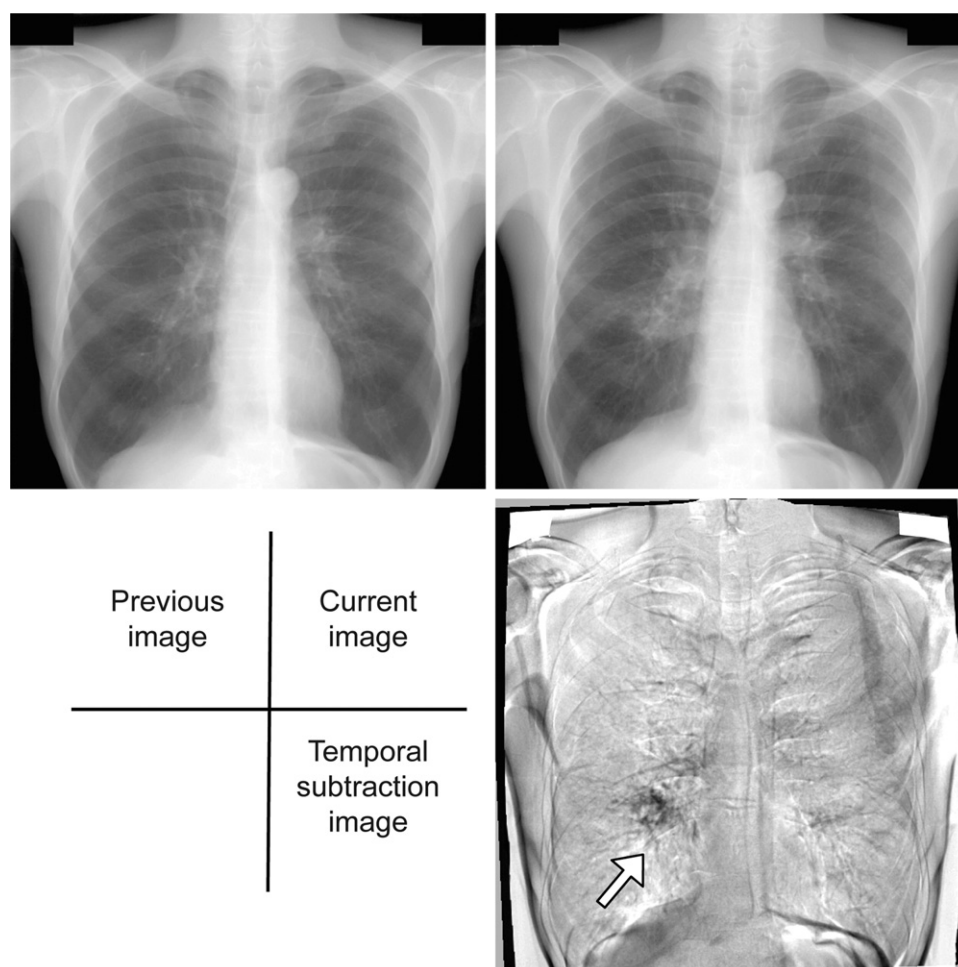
Example of temporal subtraction image in 2 sequential chest radiographs. Progression of a lung mass in right lower lung was clearly identified in the temporal subtraction image.
